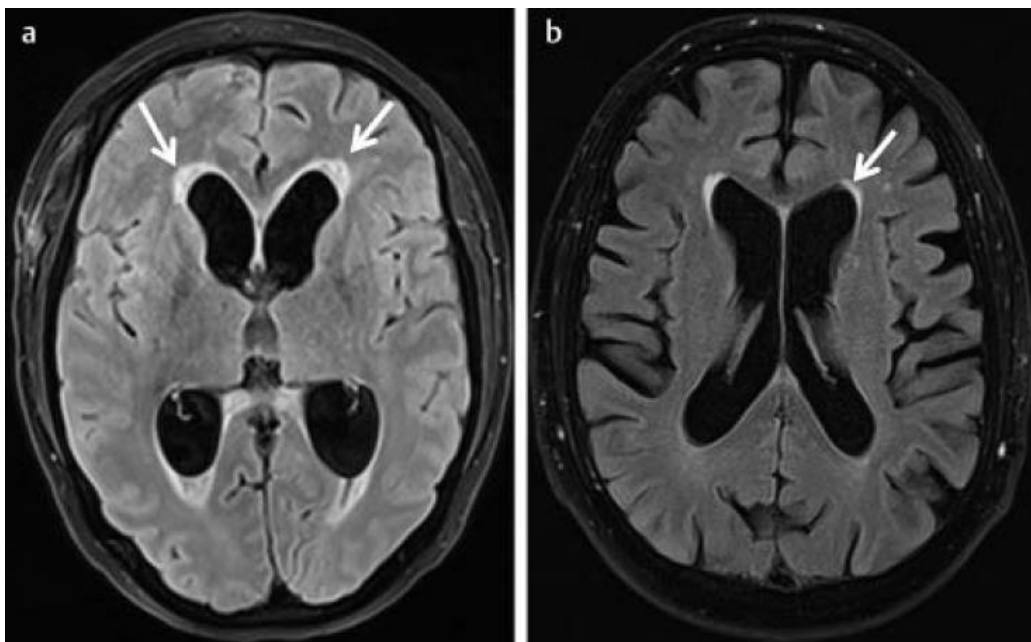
The MRI findings (T1WI) in two patients with Hakim's triad were positive (12). Both patients showed ventriculomegaly (Evan's index = 0.35). Patient 1, 75 years old male, had narrow callosal angle (85°), positive cingulate sign, and DESH. All of these signs indicate an INPH. Patient 2, a 77-year-old woman, had a blunt callosal angle (115°), negative cingulate sign, and no DESH. Patient 1 had positive results on the lumbar infusion test (LIT) and external lumbar drainage (ELD), and was treated with a VP shunt. Patient 2 was negative on both functional tests and a VP shunt was not indicated in this patient.
